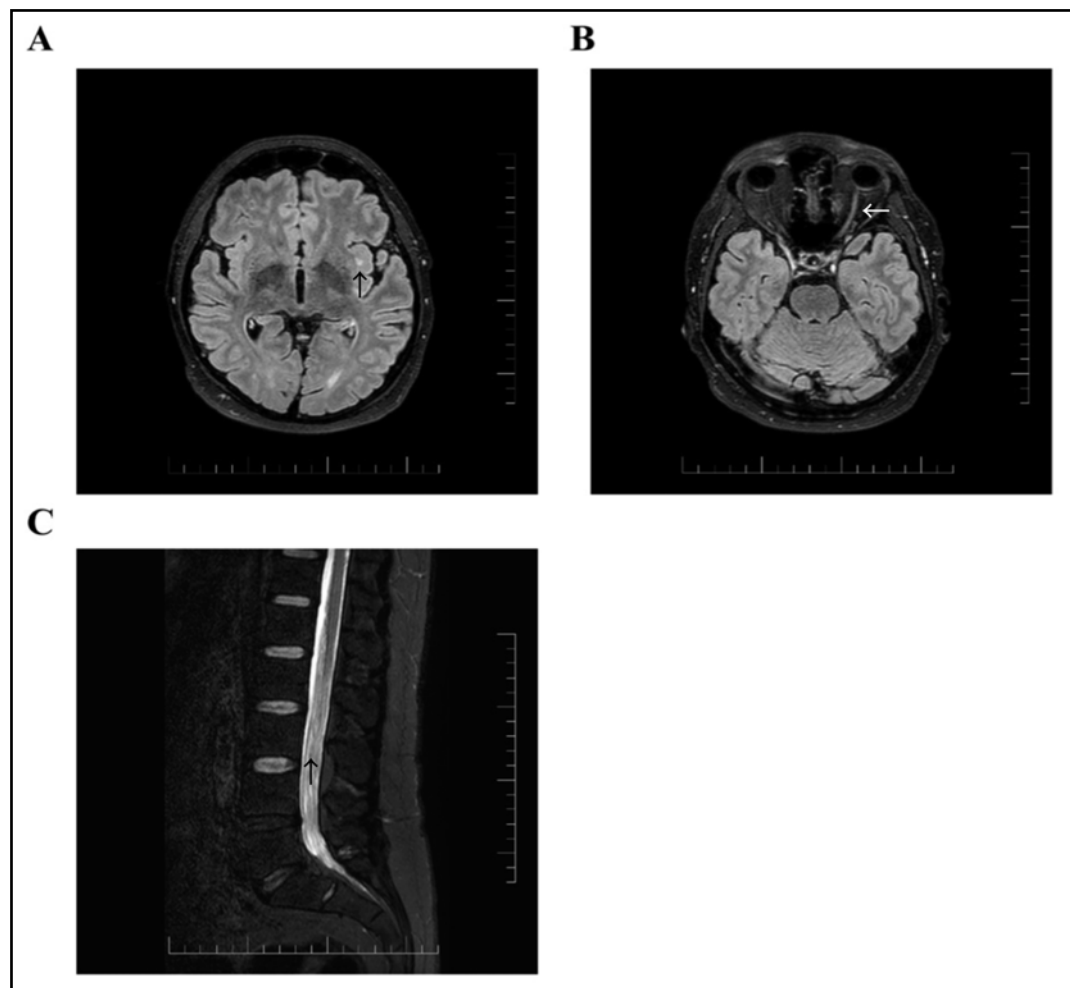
Follow-up MRI of brain (12 months after the admission): (A) New hyperintense T2 juxtacortical lesion at the proximity to left insula (arrow); (B) Follow-up MRI of brain (12 months): New hyperintense T2 lesion at left optic nerve, without post-contrast enhancement (arrow); (C) Follow-up MRI of lumbar spinal cord (12 months after the admission): Persistent finding of contrast-enhancement of cauda equina (arrow)
